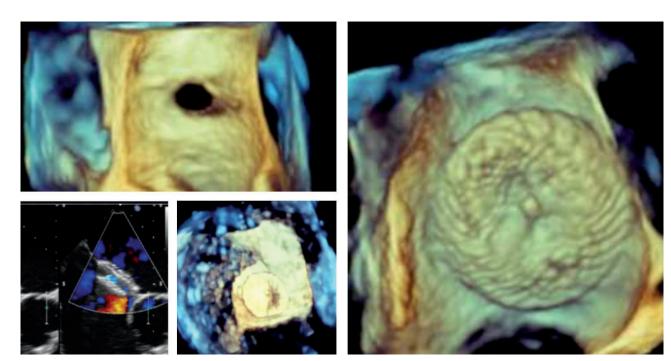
Three-dimensional transesophageal echocardiography images before and after secundum atrial septal defect closure using an atrial septal occluder
